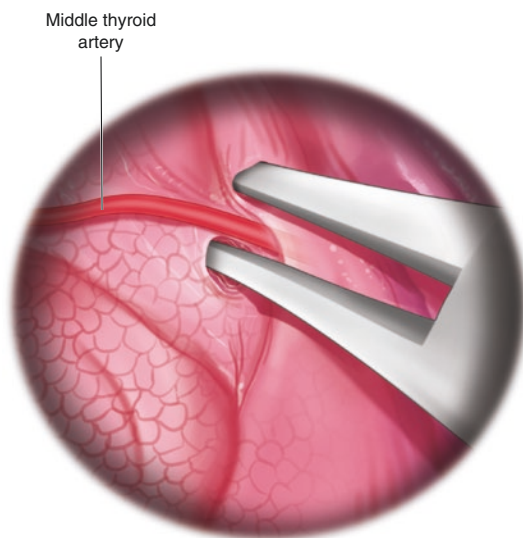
Dissection of the thyroid gland and serial ligation of its vessels can now begin. The right middle thyroid artery pictured here is to be sealed and ligated using a bipolar or ultrasonic energy device
